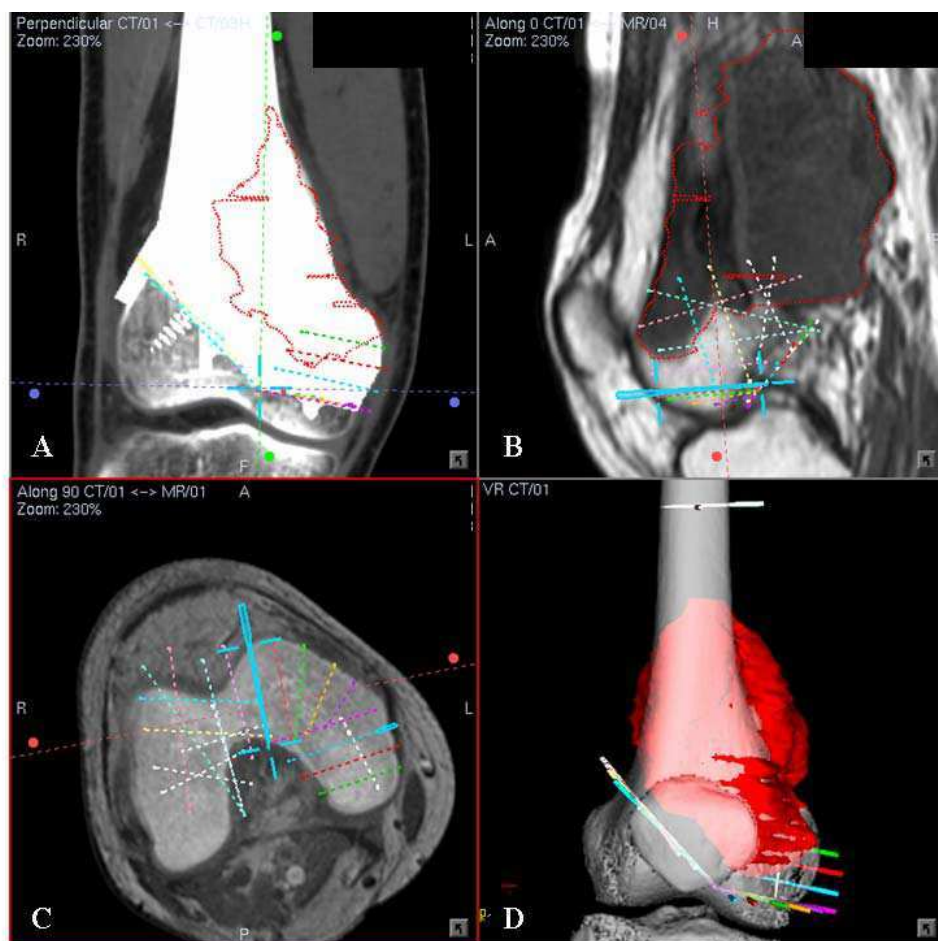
(A) A coronal section of the CT images with incorporation of CAD prosthesis for Patient 16 with right distal femur parosteal osteosarcoma is shown. Conversion of CAD data of custom prosthesis to DICOM format was made possible using CAD software (MIMICS® - Materialise's Interactive Medical Image Control System). This allowed direct use of CAD data for navigation planning of tumor resection. The central cross represented the virtual marker (pedicle screw in the CT spine navigation software) that marked one of the locations of intended bone resection. (B) A sagittal section of the MR images showed the extent of the tumor. (C) A axial section of CT / MR image fusion at the intended resection of distal femur is shown. (D) A 3-D bone tumor model reconstructed from CT and MR image data sets is shown. The tumor volume was red in color. By analyzing the 2-D CT / MR fused images and 3-D model, a joint-saving resection with multiplanar osteotomies were planned at distal femur and intended bone resections were marked with virtual screws. The more precise the bone resection was, the greater number of virtual screws was needed to define the plane of resection
